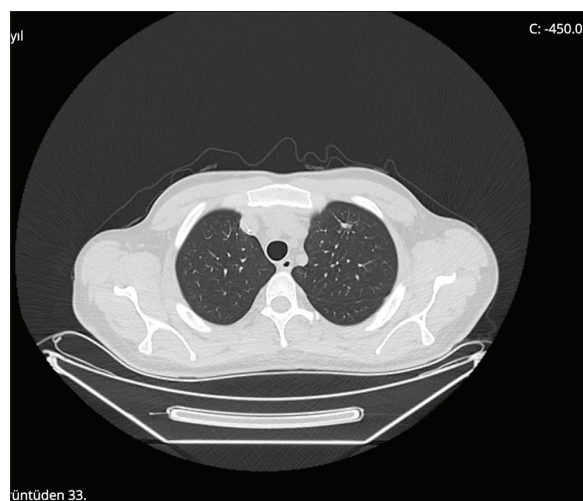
Thorax CT shows marked regression of the nodular lesion at the apex of the right lung.
